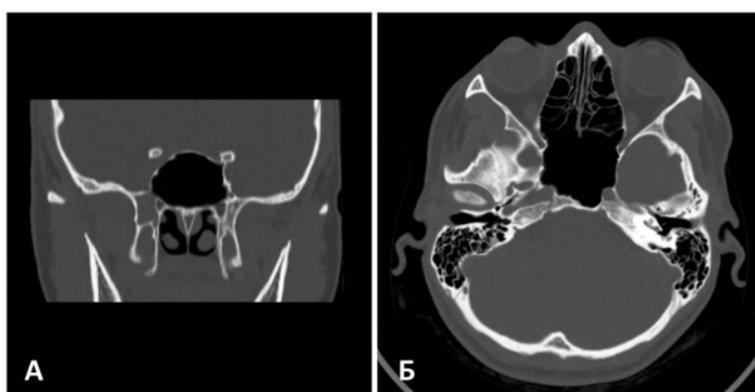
Computed tomography of the paranasal sinuses of patient P. after surgical treatment. A - coronal projection, B - axial projection.
